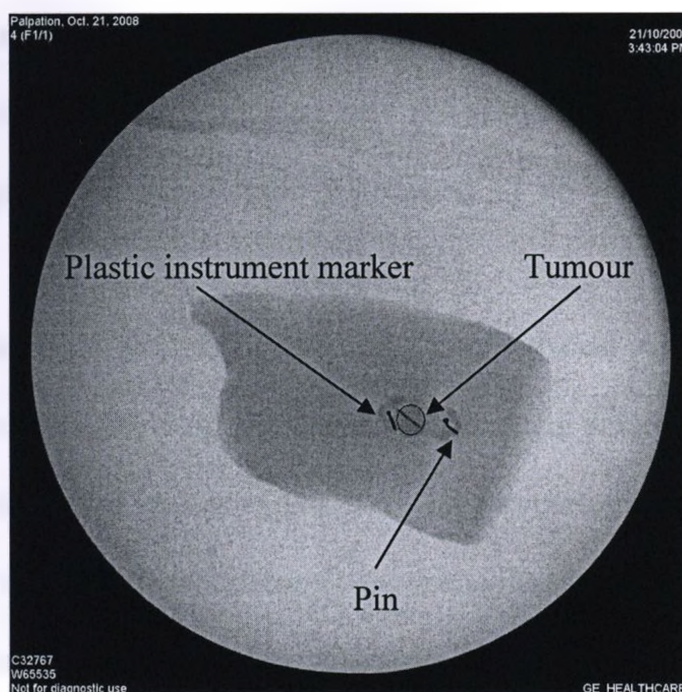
Radiographic image of liver sample with embedded tumour.
